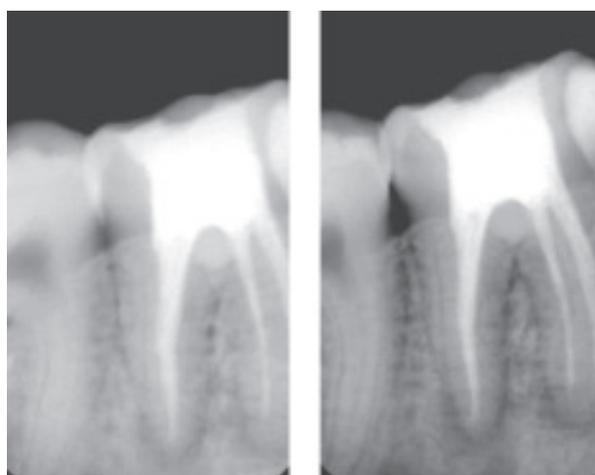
Final X-ray (RVG-View)
